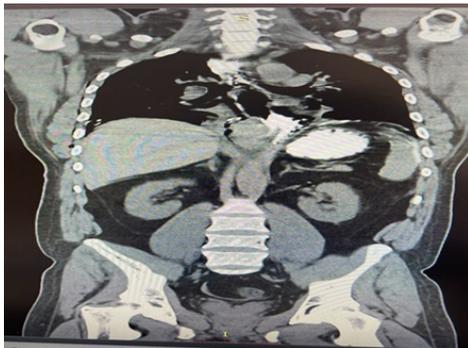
Preoperative CT scan showing right hemopneumothorax and distal esophageal leak.
